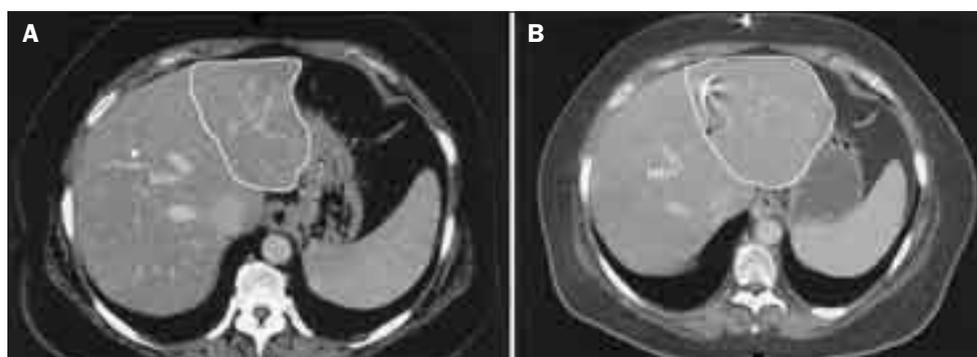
CT scans before (A) and after (B) portal vein embolization to improve expected liver remnant volume. MHV indicates middle hepatic vein.
